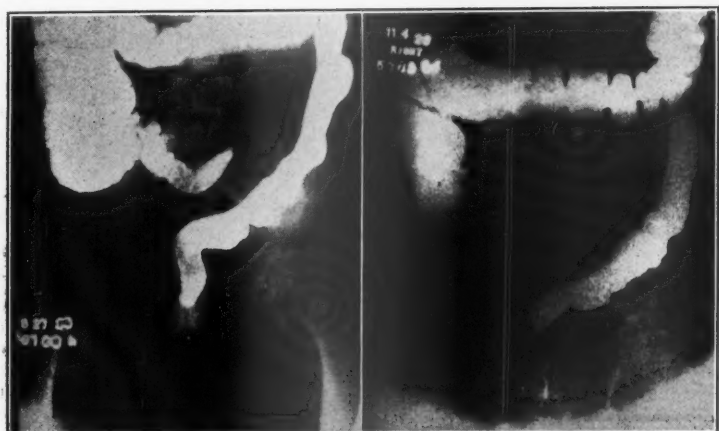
Radiographs following Barium enemas before and after treatment (Bargen).
